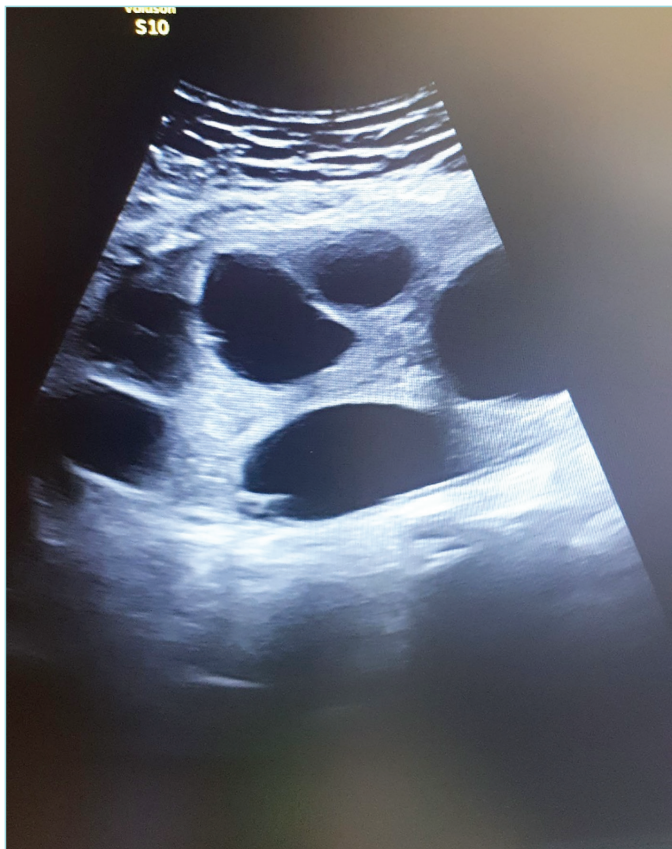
Ultrasonographic appearance of theca lutein cysts.
